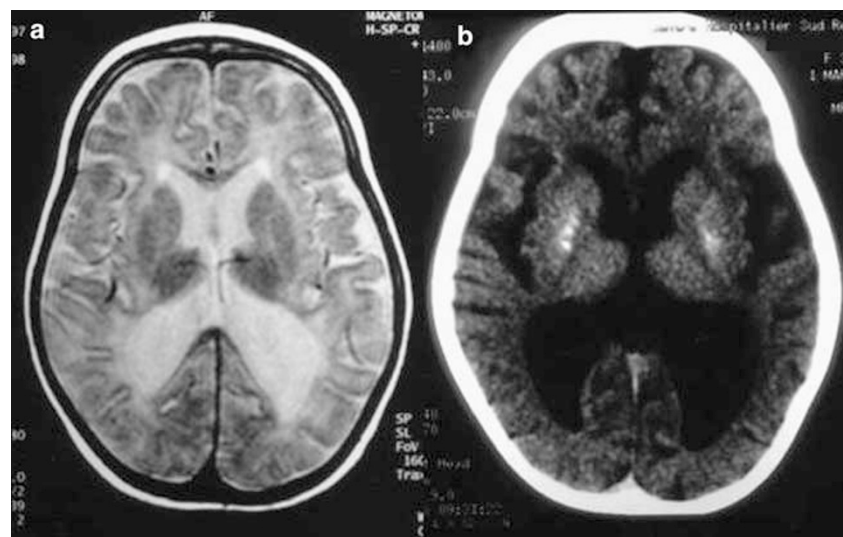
(a) T2-weighted brain MRI of patient 2 at 18 months showing diffuse hypersignal of the white matter, moderate cerebral atrophy and dilated ventricles. (b) CT scan of patient 2 at 3 years of age, showing bilateral calcifications of the putamina and severe cerebral atrophy with enlarged ventricles.
